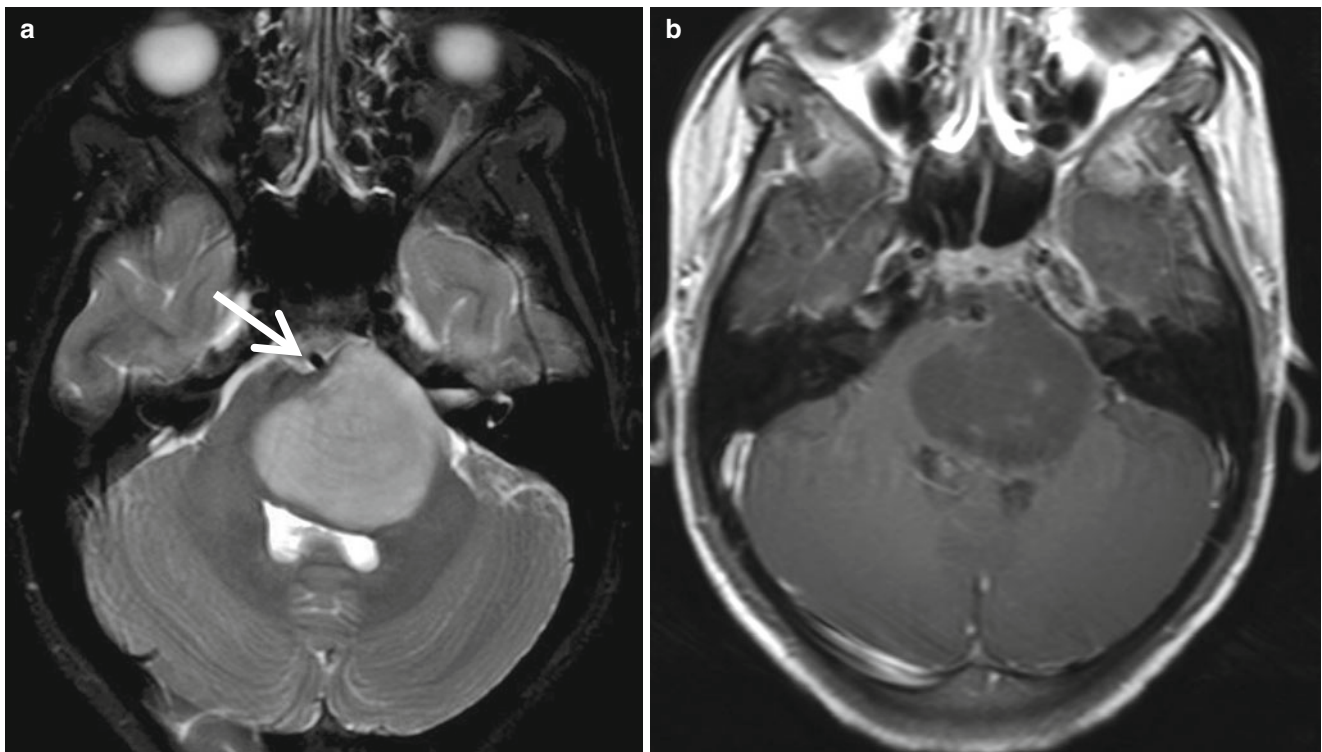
Diffuse pontine glioma. (a) Large pontine mass is seen as high intensity expanding the pons on T2-weighted image. The basilar artery (arrow) is partially engulfed. (b) The mass is not well enhanced on postcontrast image
